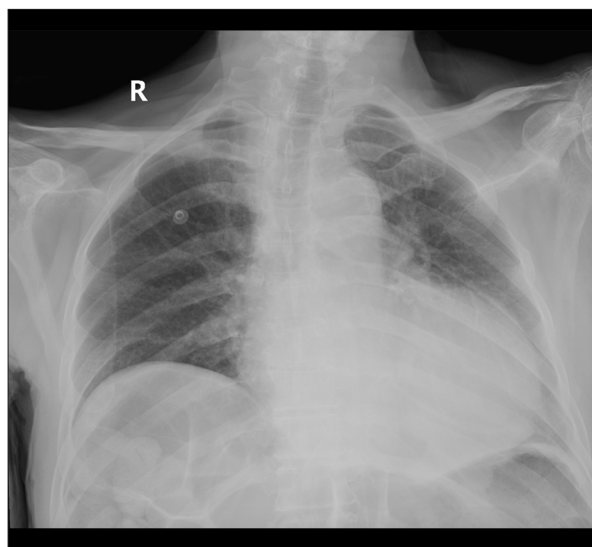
Chest X-ray showing globular cardiac silhouette, elevated diaphragm, and bowel dilatation.
